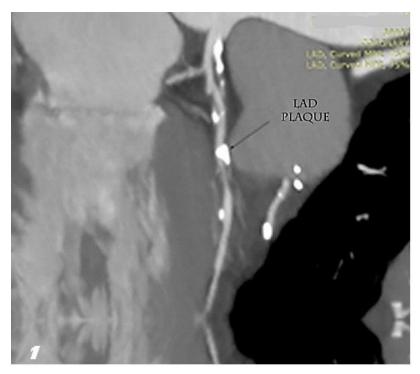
Case no. 1 A heavy smoker 55 years old male presented with chest pain. CT coronary angiography multiplanar reformatted (MPR) image shows extensive calcified plaques (non ulcerating) along the whole length of the left anterior descending artery (LAD), of variable length & exerting different significant lesions of different grades of stenosis, the worst is at its mid portion (black arrow). His Calcium score= 645 and Vitamin D level= 12ng/dl (Insufficient).
